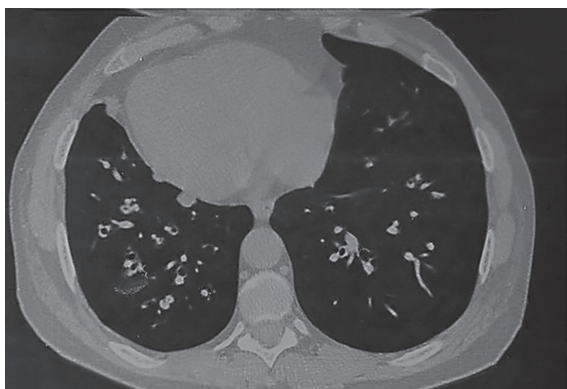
High-resolution computed tomography of the lungs in a mustard gas-exposed case, 25 years post exposure. Diffuse cylindrical bronchiectasis is observed in the lower lobes of both lungs. (from the private collection of the corresponding author)
